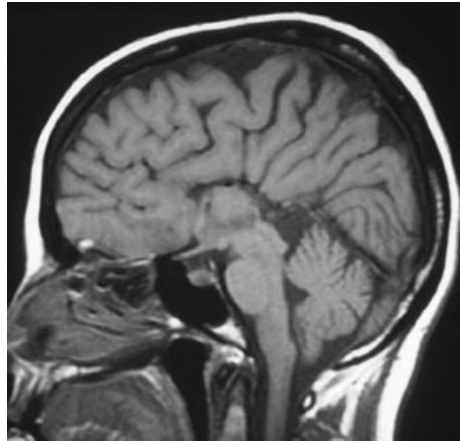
MRI image of agenesis of corpus callosum
